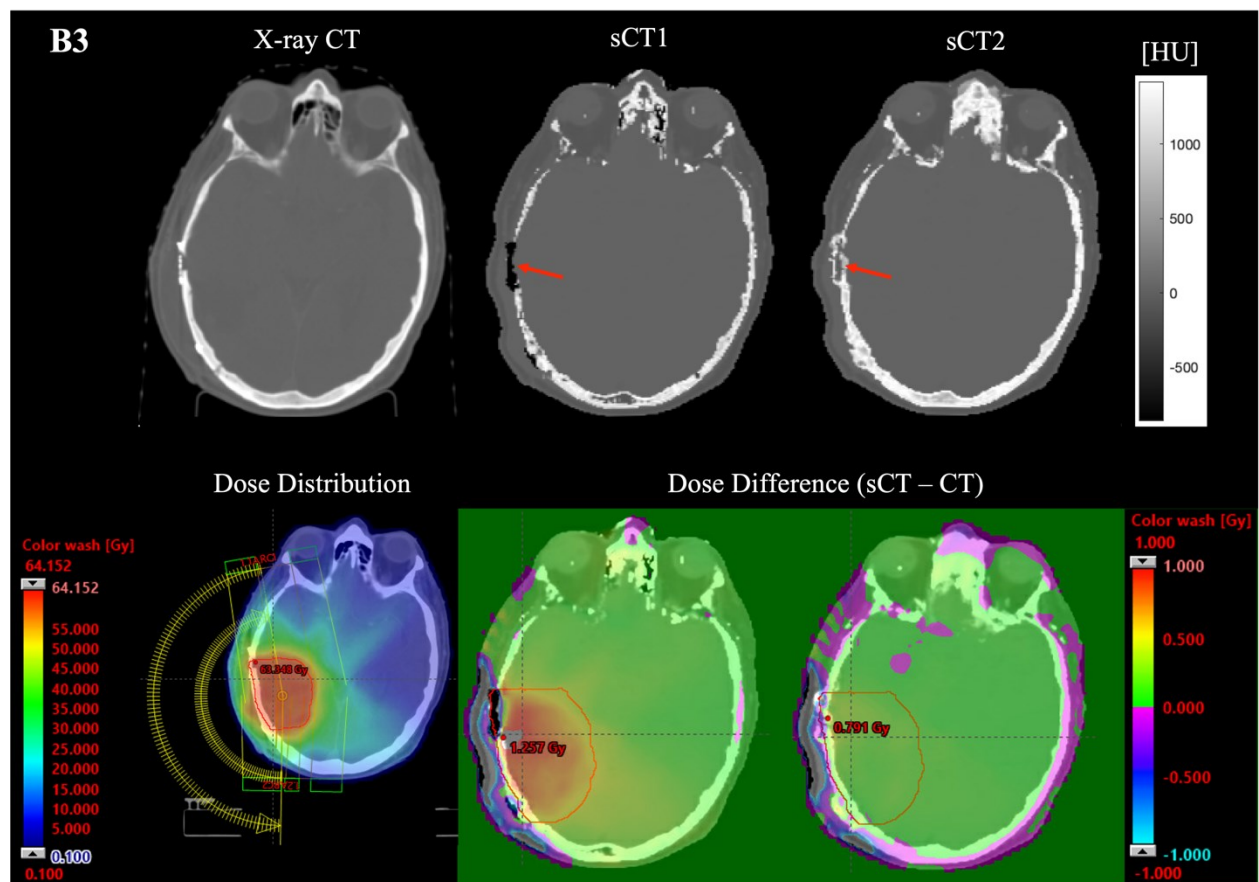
X-ray CT and sCT images for patient B3. Regions of Ti implants were erroneously replaced by air in sCT1 and soft tissue and bone in sCT2 (1st row). The dose distribution was calculated on the planning CT image and dose difference maps were calculated for sCT1 and sCT2, as compared to the dose distribution on X-ray CT (2nd row).
